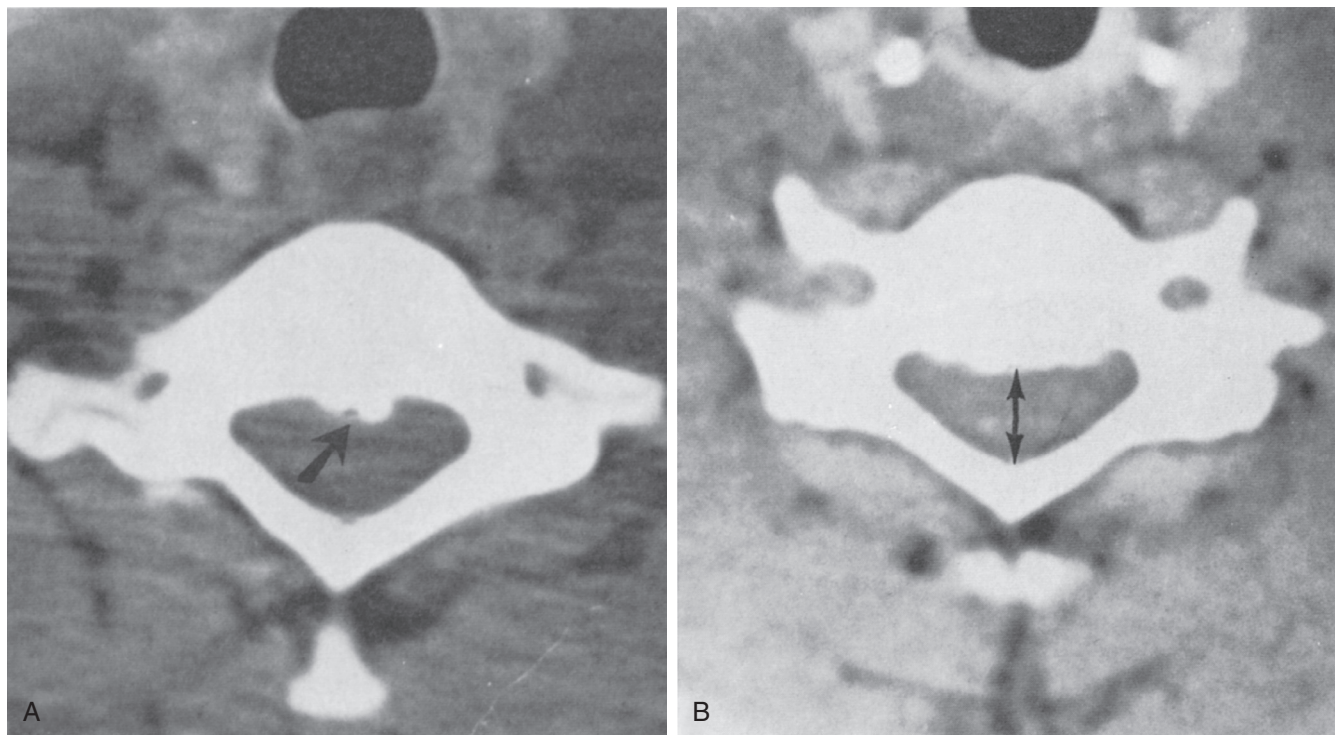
■ Computed tomographic scan showing osteophytic ingrowth (arrow) in the spinal canal (A) and narrowing of the anteroposterior diameter of the spinal canal (B; double-headed arrow) in a patient with the typical clinical picture of thoracic outlet syndrome.
